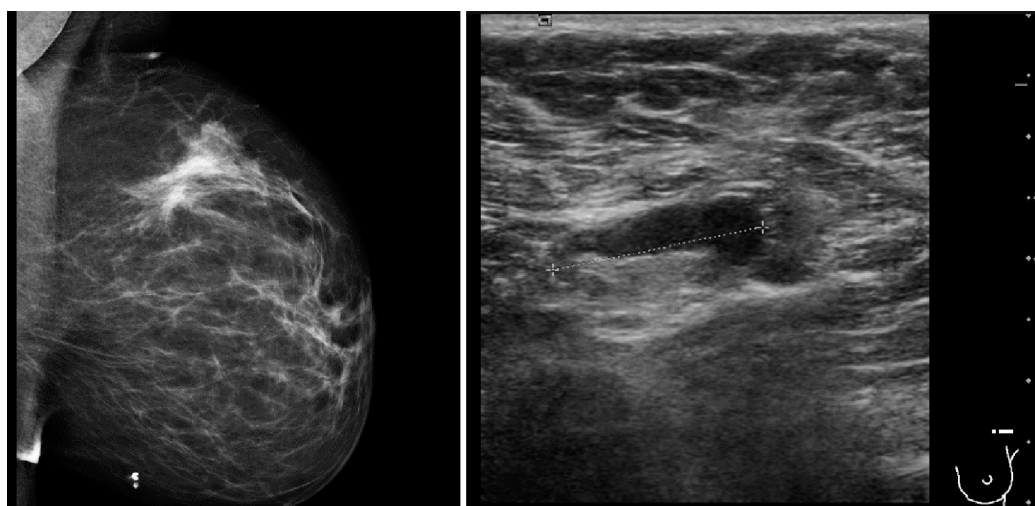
Breast mammography (left) and breast ultrasound (right) at diagnosis
